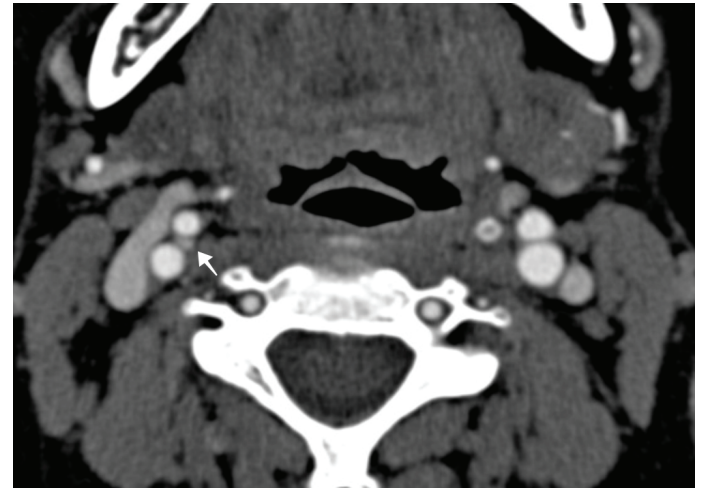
Axial CT image. Normal CB (arrow) in the right carotid bifurcation.
